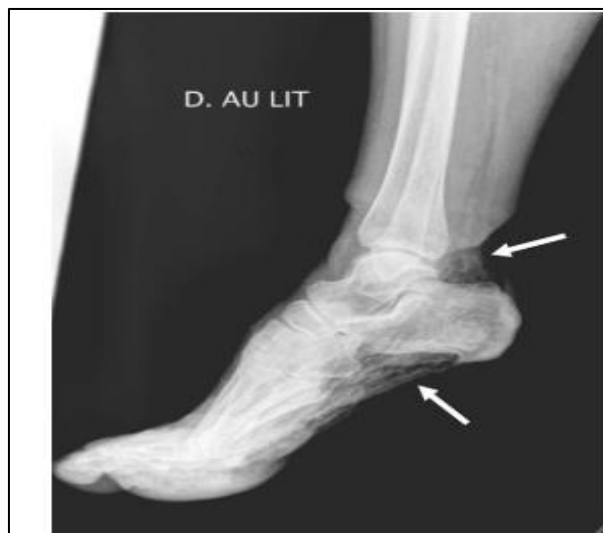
Standard X-ray of a right foot showing the presence of gas
